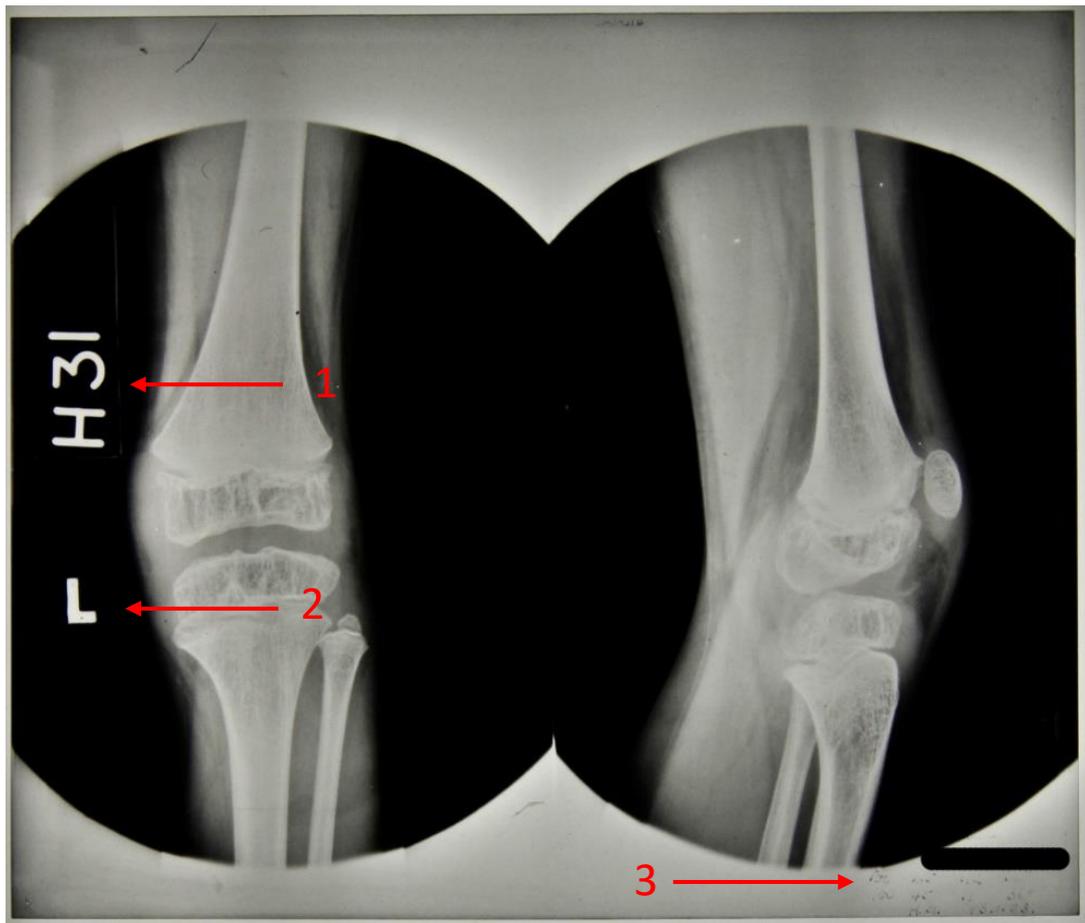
An example of the information available from the radiographs. 1. Serial number, 2. Anatomical marker indicating the side of the body affected. 3. Serial number, date and x-ray exposure handwritten after the radiograph had been processed – as can be seen in this example this was not always clear or legible (HOSP/STAN/7/1/2/1662_19)
